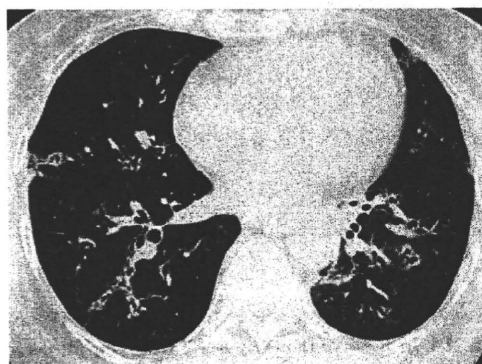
Nonspecific interstitial pneumonia (NSIP) associated with SjS in a 62-year old woman. Transverse thin-section CT (1-mm collimation) at the level of the inferior pulmonary vein demonstrates intralobular reticular opacity with traction bronchiectasis (arrows) with a predominantly peribronchovascular distribution.
